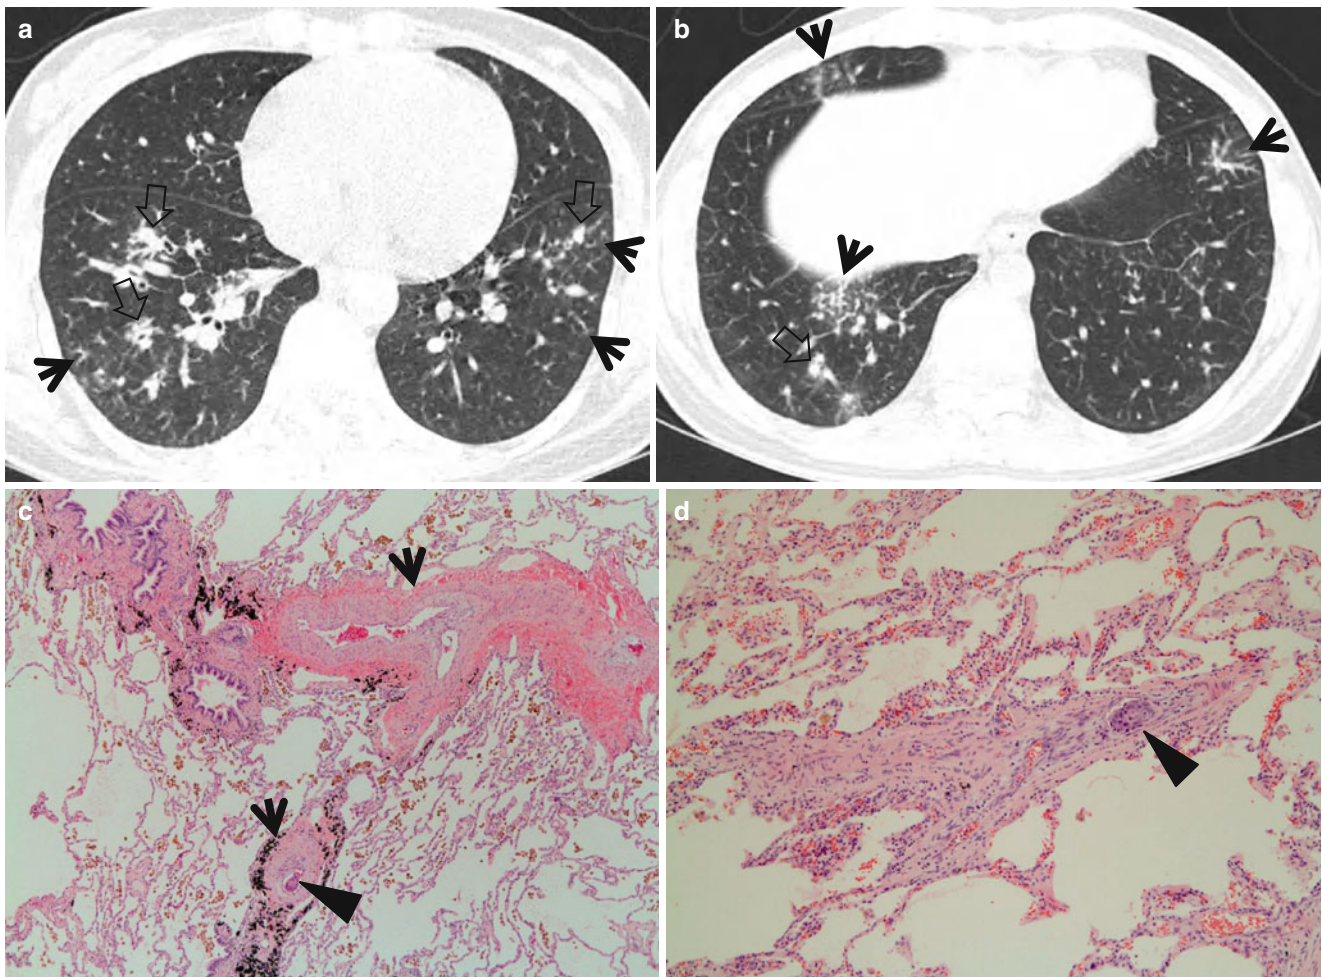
Tumor emboli and lymphangitic carcinomatosis along bronchovascular bundles showing vascular tree-in-bud signs in a 34-year-old woman with gastric cancer. (a, b) Lung window images of thin-section CT scans (1.5-mm section thickness) obtained at levels of cardiac ventricle (a) and liver dome (b), respectively, show thickened axial interstitium (bronchovascular bundles) (open arrows) and several foci of tree-in-bud signs (arrows) in both lungs. (c) High-magnification
